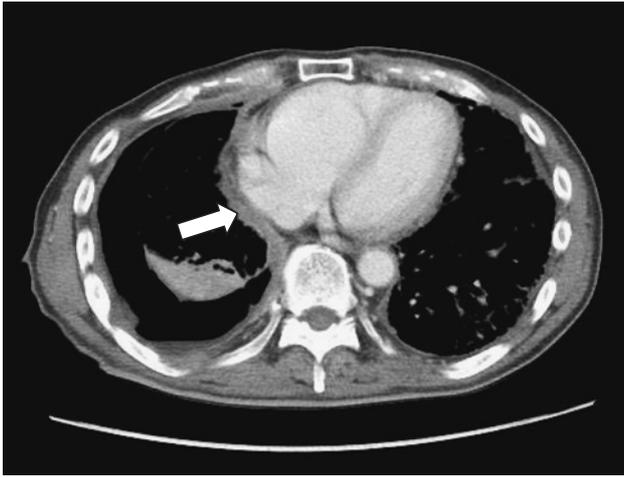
Chest computed tomography scan on admission. Thickening of the right pleura with effusion was observed (arrow).
